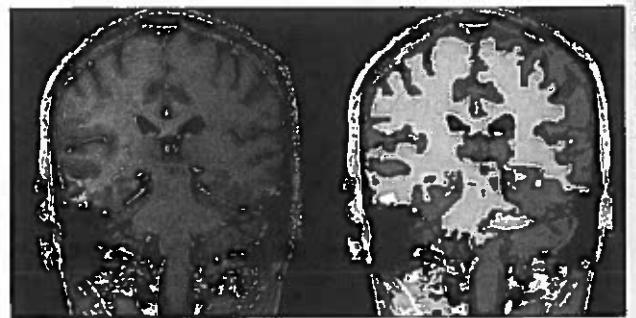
Fixed σ adaptive clustering applied to a degraded MRI brain scan. Note overdevelopment of gray matter on the right and underdevelopment on the left, causing partial loss of both hippocampi.
